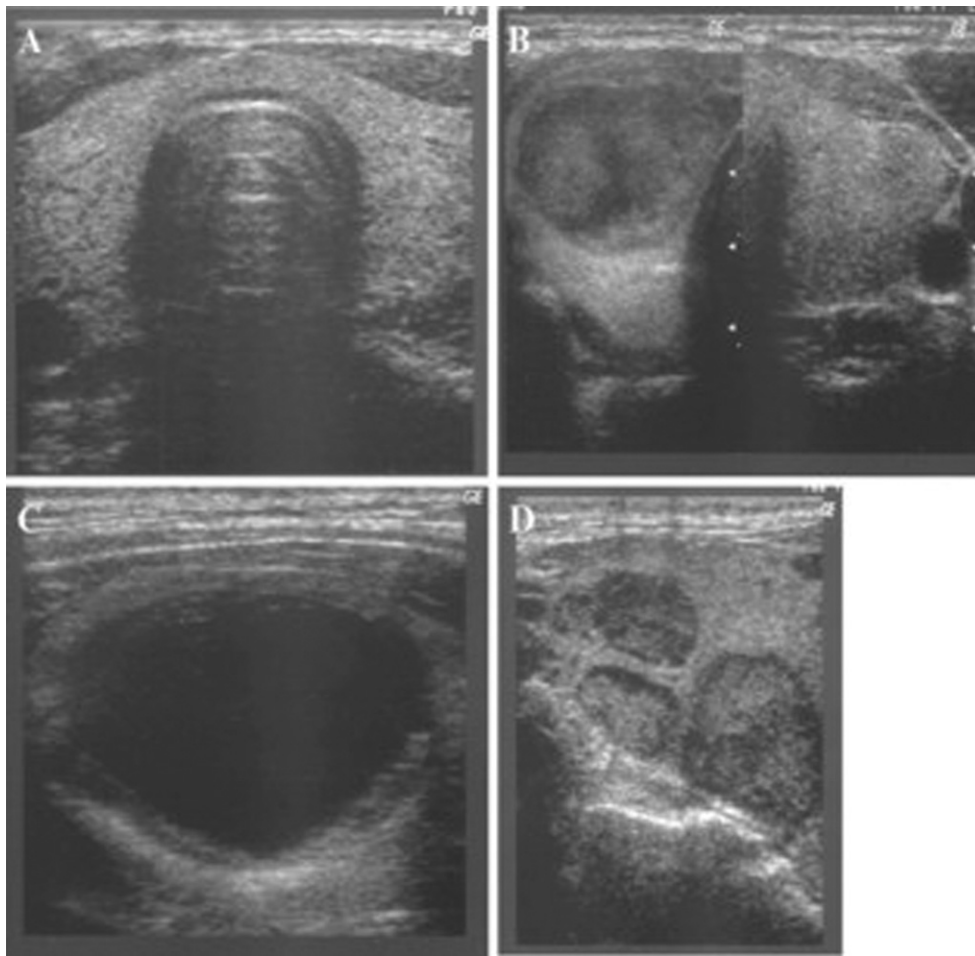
Various appearances (morphological patterns) of a thyroid nodule using ultrasonography. (A) Normal thyroid tissue. (B) Solitary solid hypoechoic (*dark*) thyroid nodule in the right thyroid lobe (left) surrounded by normal thyroid tissue (medium *gray*). (C) Solitary cyst (*black area*) surrounded by normal thyroid tissue. (D) Multiple nodules with varying echogenicity (multinodular gland).
